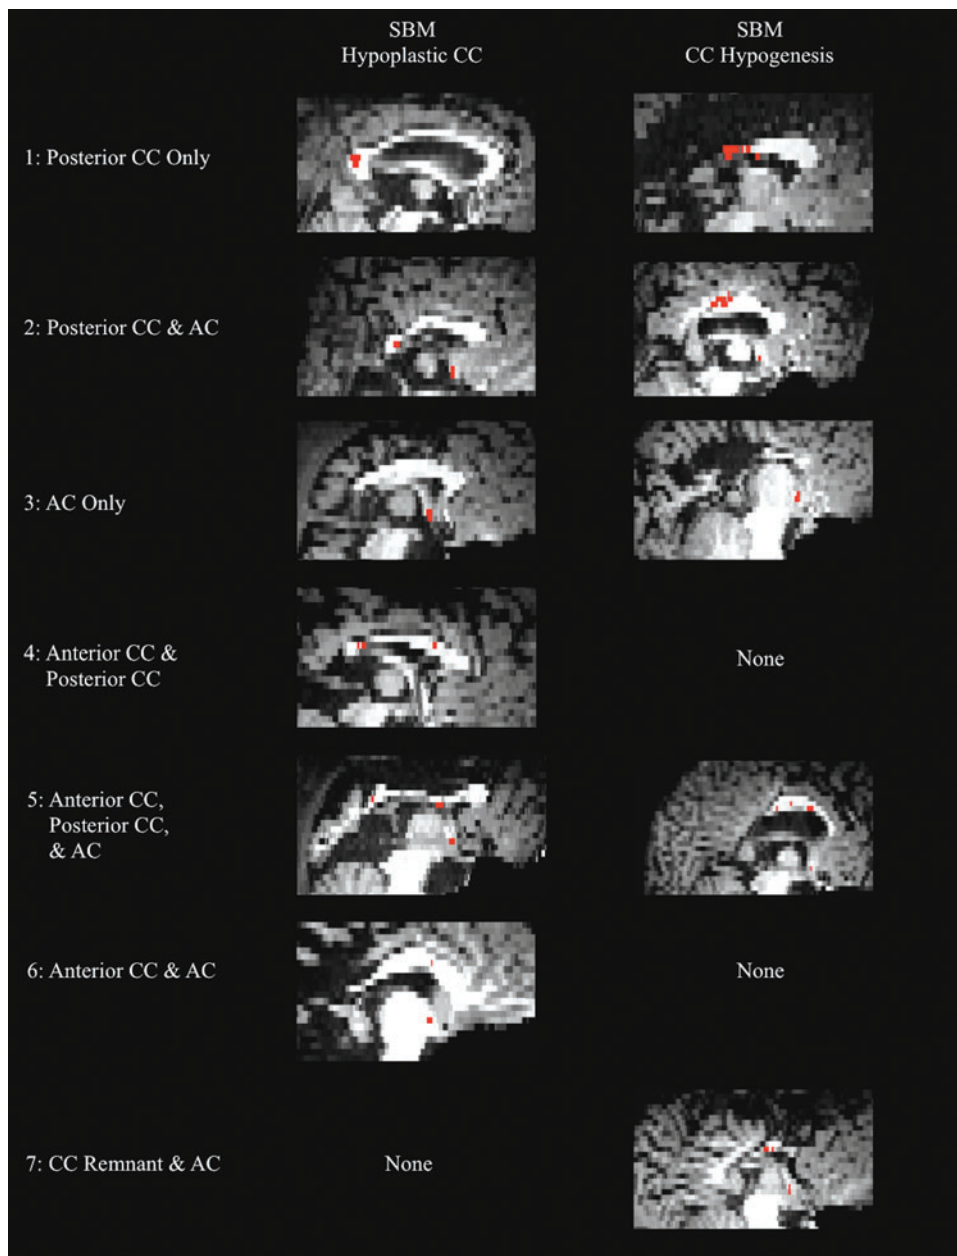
Interhemispheric temporal tracts in SBM. Midsagittal T1-weighted images coregistered to diffusion space of the seven different interhemispheric tract patterns present in participants with SBM. The *left column* of images shows patterns present in individuals with SBM and CC hypoplasia. The *right column* shows patterns present in individuals with SBM and CC hypogenesis. AC, anterior commissure; *Red*, interhemispheric temporal tract. Color images available online at www.liebertpub.com/brain
